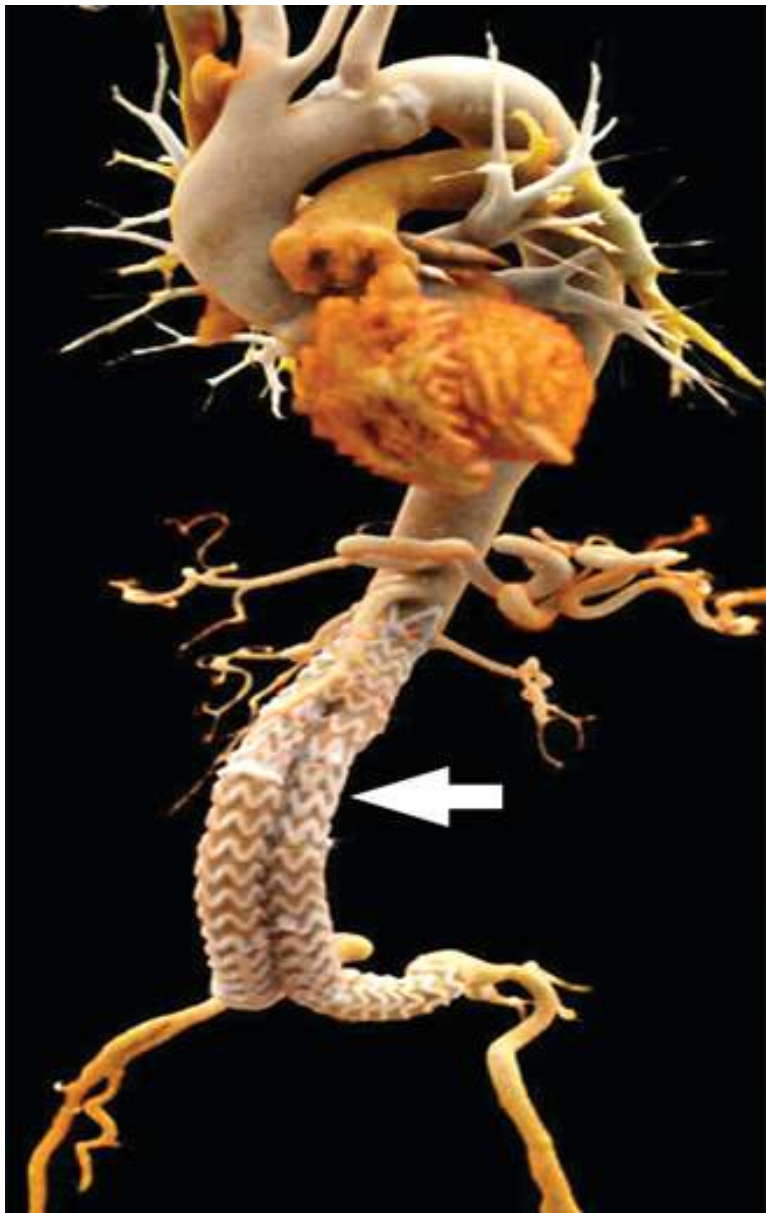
76-year-old man undergoing CT angiography of aorta after endovascular repair of infra renal aneurysm.
